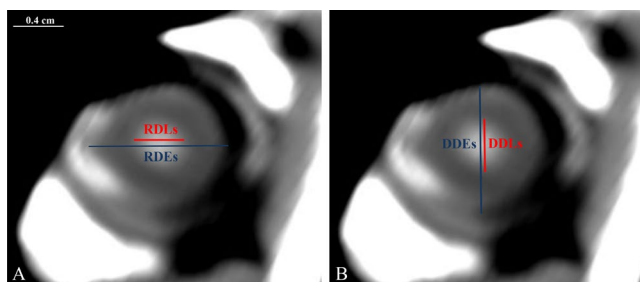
Sagittal CT scan of Nile tilapia. (A) Horizontal measurements of the rostrocaudal distance of the eyeball (RDEs) and the rostrocaudal distance of the lens (RDLs). (B) Vertical measurements of the dorsoventral distance of the eyeball (DDEs) and the dorsoventral distance of the lens (DDLs).
